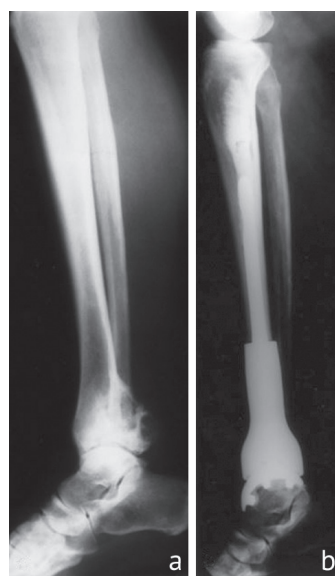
X-ray of the ankle of a patient with chondromyxoid fibroma. Condition after arthroplasty with an oncological prosthesis (2 months after surgery) [64]
